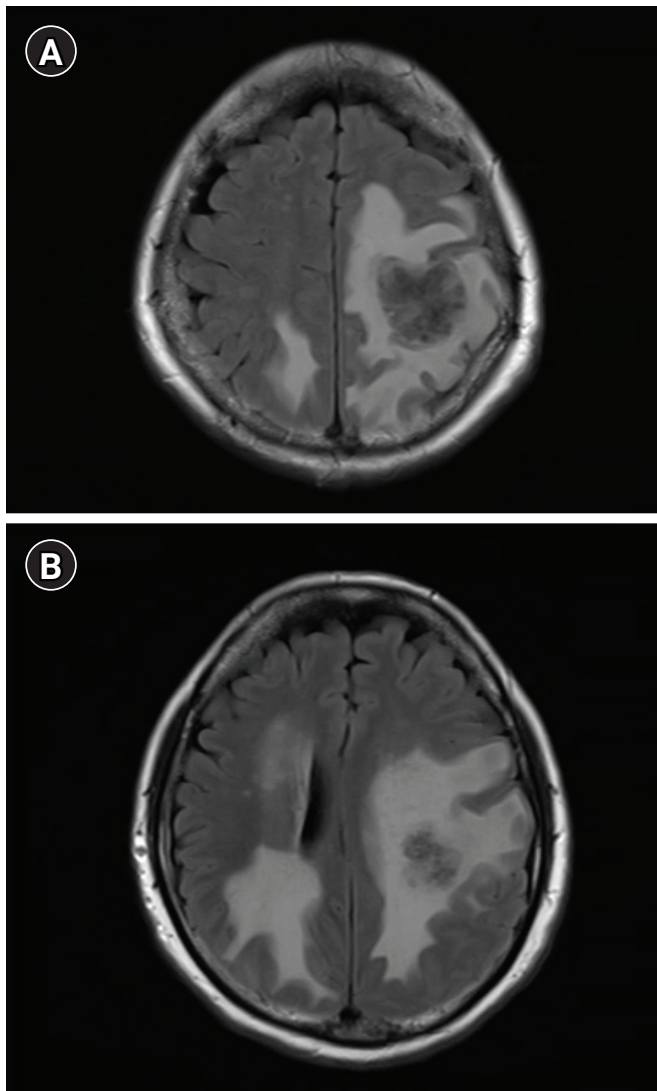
Magnetic resonance imaging of the brain in case 1 (axial view). Fluid-attenuated inversion recovery images show (A) brain metastasis in the left parietal lobe, involving the primary motor cortex, and (B) peritumoral edema involving the white matter.
